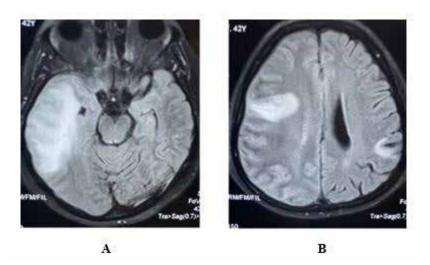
Image A: MRI showed a large hemorrhagic mass (55 * 40 mm) in the right temporal lobe surrounded by edema and mass effect. Image B: MRI showed a hemorrhagic mass in parietal lobessurrounded by edema and mass effect with a small lesion in the left perirolandic cortex
